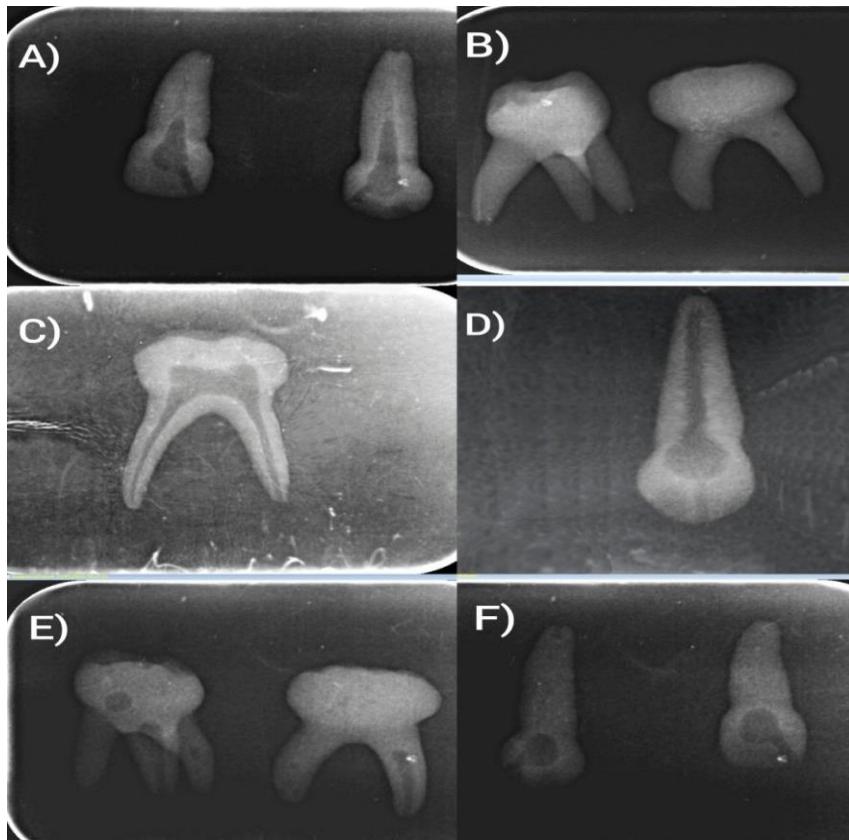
Radiographic images of artificial teeth. A) 51 and 53 in Bio Crown resin; B) 54 and 84 in Bio Crown resin; C) 84 in Model resin free of residues in the ducts; D) 53 in wax-filled Model resin 7; E) 54 and 84 in Model resin filled with PVA; F) 53 and 51 in Model resin filled with PVA.
